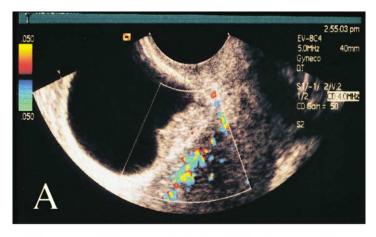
(A) Transvaginal sonographic image of deep endometriosis within the posterior bladder wall. At color Doppler imaging, normal myometrial flow is seen, whereas the endometriosis lesion has limited vascularity. (B) Transvaginal sonography shows a sagittal view of the uterus, bladder endometriosis (*left*), and deep rectovaginal endometriosis (*right*).
